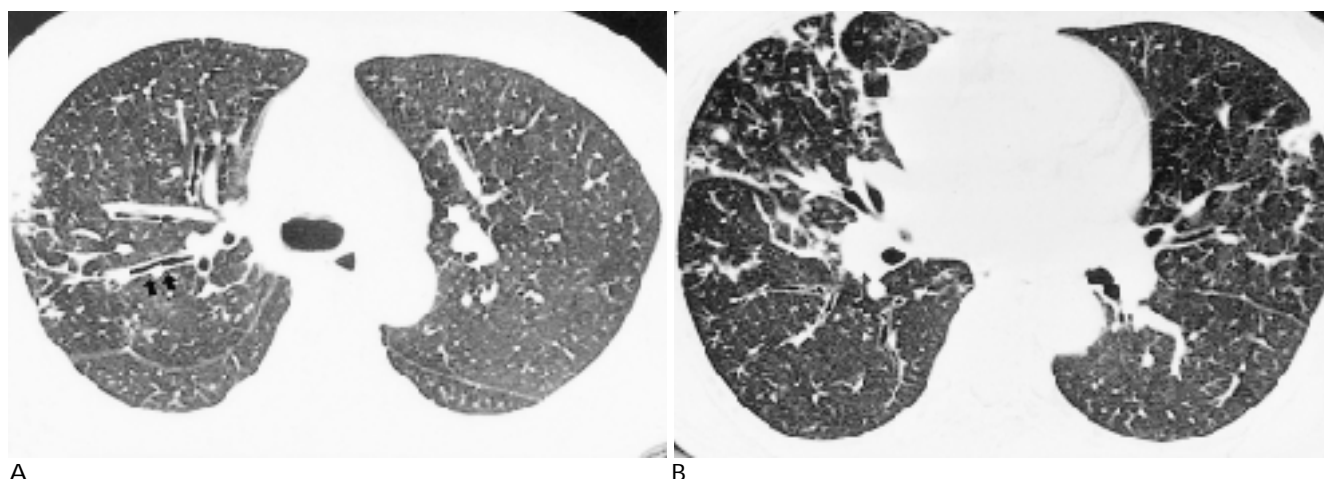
MOTT in a 43-year-old woman. HRCT scans at the level of carina (A) and right middle lobe bronchus (B) show bronchiectasis with wall thickening (arrows) in the right upper lobe, right middle lobe and right lower lobe. Also note wide spread micronodules and tree-in-bud appearance involving right middle lobe. Sputum cultures were repeatedly positive for MAI.
